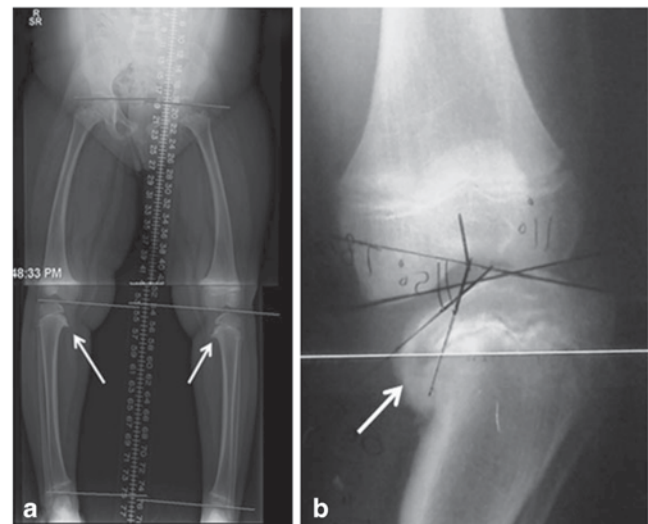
Radiological changes in Blount's disease. a Long radiographs (scanogram) of a 3-year-old girl showing the proximal tibial metaphyseal beaking (arrow). b A 4-year-old boy with depression of the medial tibial plateau and fusion of the growth plate on the medial side (arrow). Note the difference between the medial and lateral sides of the tibial growth plate
